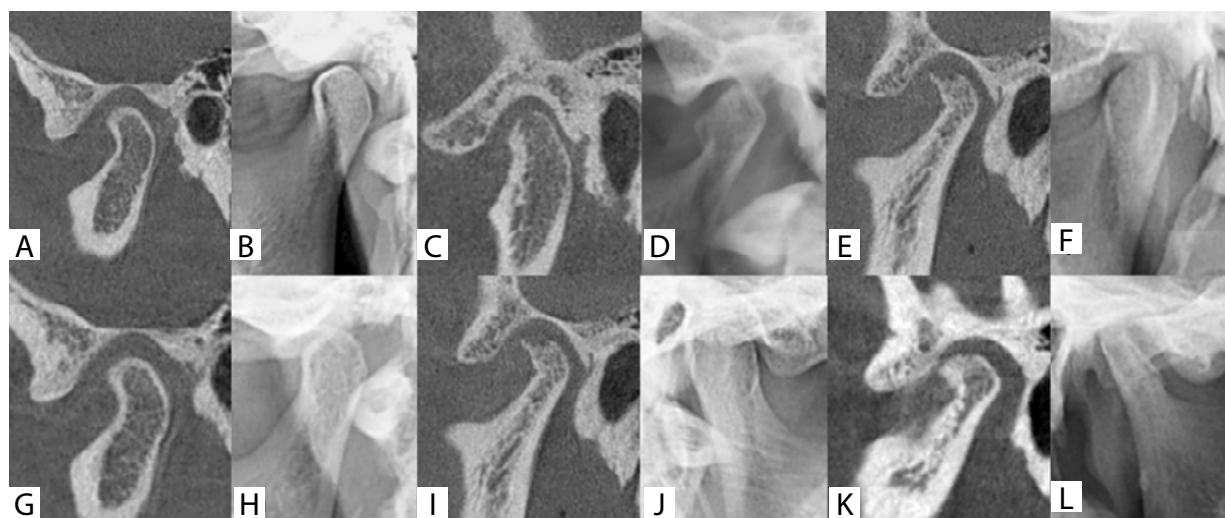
Mandibular condyle and articular eminence cortication types in cone beam computed tomography sagittal section and cropped panoramic radiograph: A-B) type 1 cortication on mandibular condyle, C-D) type 2 cortication on mandibular condyle, E-F) type 3 cortication on mandibular condyle, G-H) type 1 cortication on articular eminence, I-J) type 2 cortication on articular eminence, K-L) type 3 cortication on articular eminence
